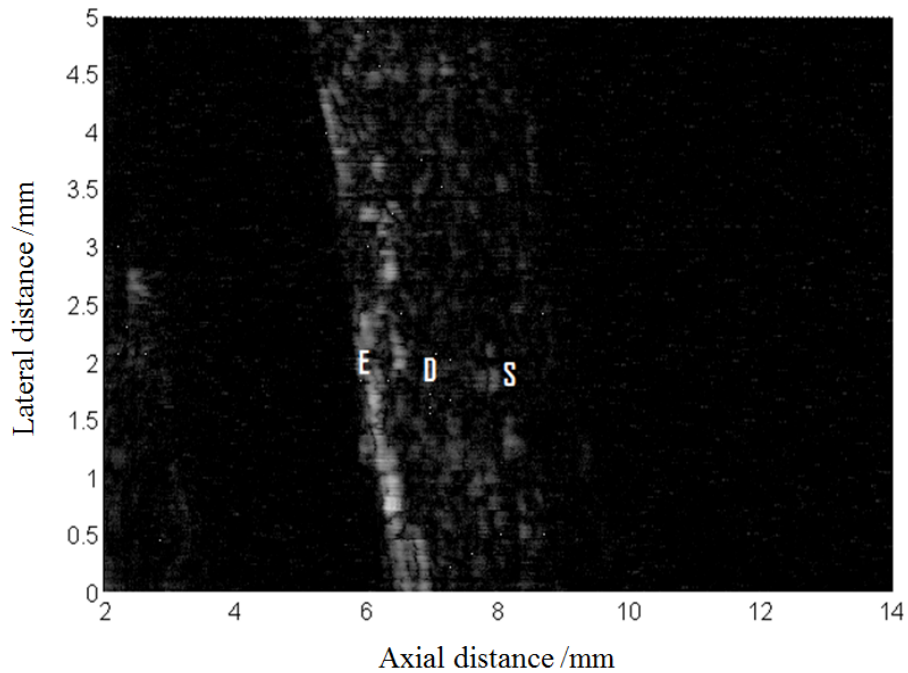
B-scan of the different layers of a section of forearm from high frequency ultrasound imaging system with 50MHz; E: epidermis, D: dermis and S: subcutaneous fat
